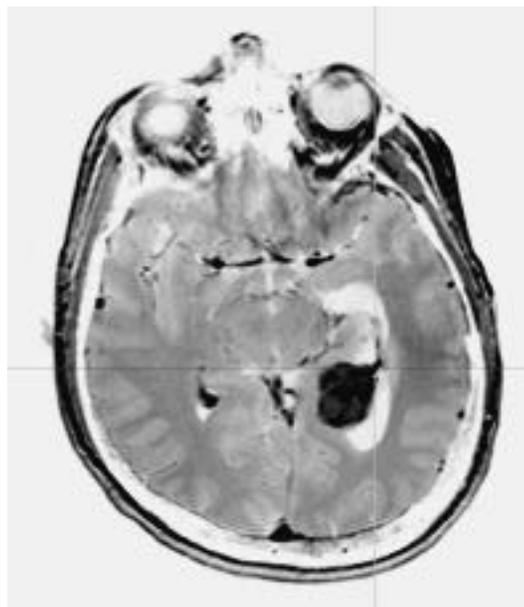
Magnetic resonance imaging shows an incidental finding in a 37-year-old male harboring the smallest tumor in our series (2 cm). There is enlargement of the left temporal horn. This more medially localized tumor (type C) was resected uneventfully by an interhemispheric transcallosal approach (see also Fig. 32.2A,B).
